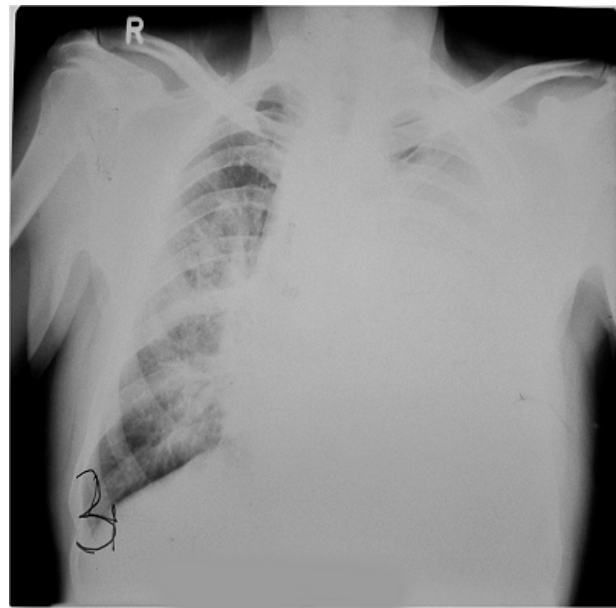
Chest radiography: left-sided massive pleural effusion.
